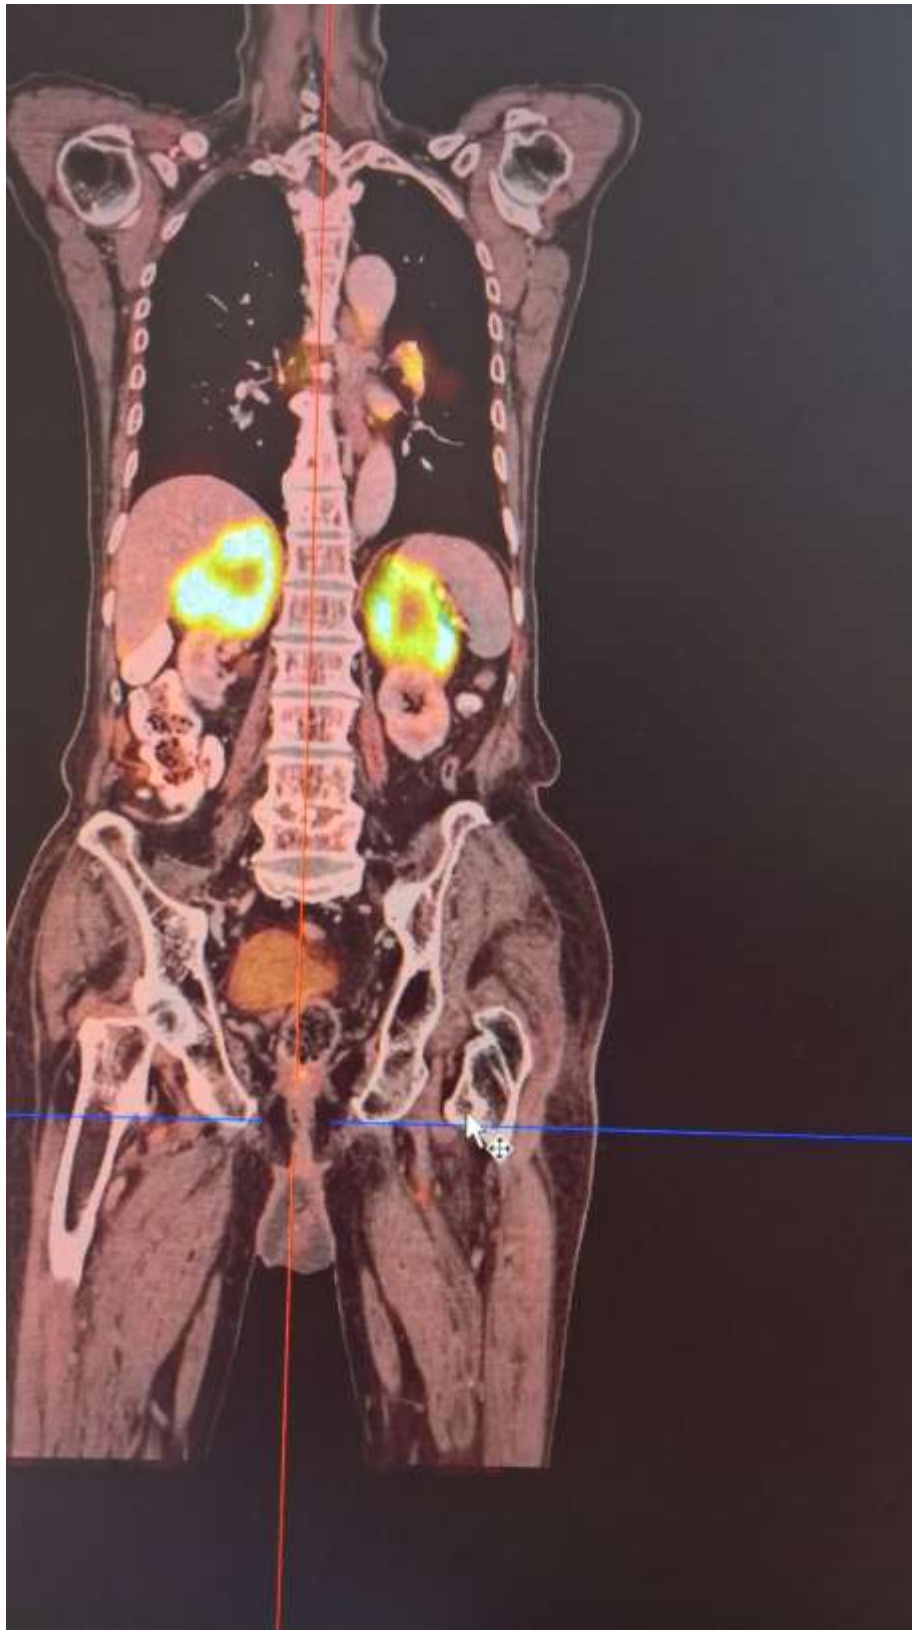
FDGPET-CT Thorax: Showing primary in Lung
